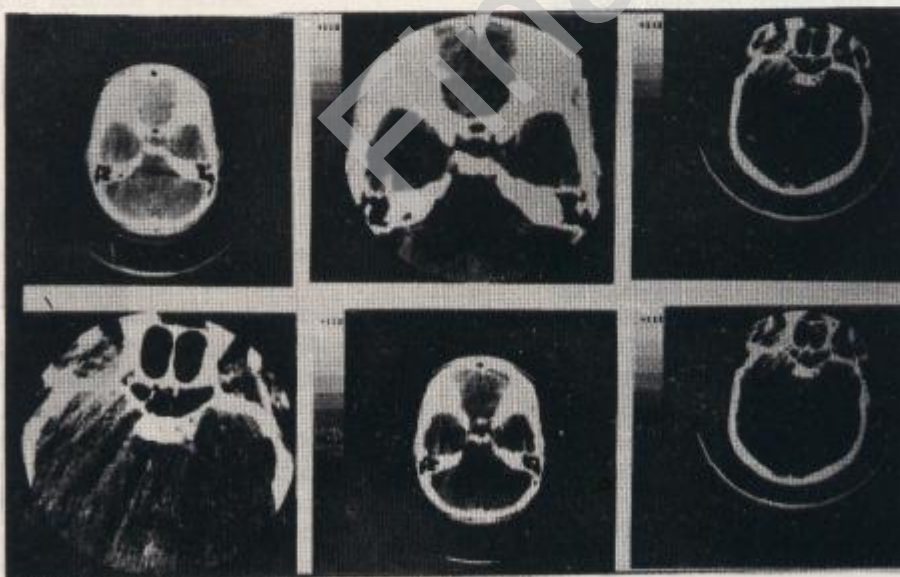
CT scan of case 18 showing a pituitary adenoma.
